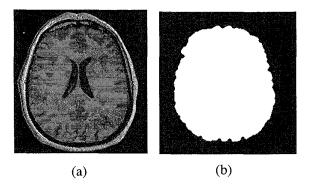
(a) Initial MR image, (b) Brainmask. (shown on one slide of the 3D volume).
